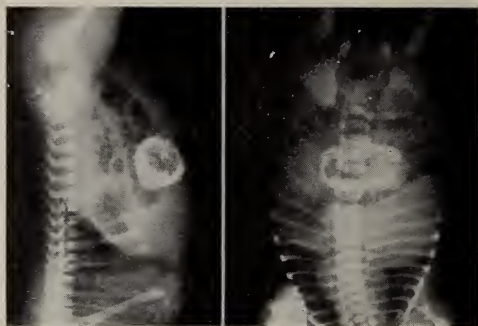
Roentgenograms of infant's abdomen at birth.
